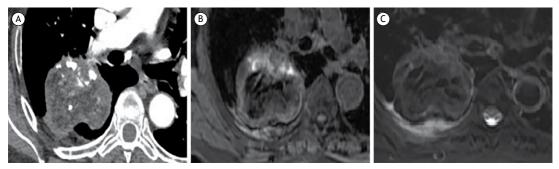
In A, axial CT scan of the chest (mediastinal window) showing calcification within a large lesion in the right lower lobe. In B and C, magnetic resonance imaging of the calcification seen on CT. Note that the lesion is hyperintense on T1- and T2-weighted images (B and C, respectively).
